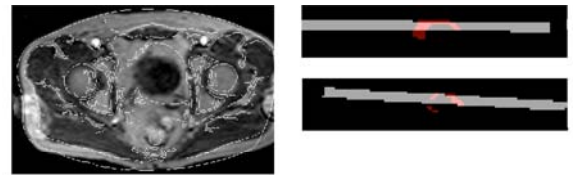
CT edges (Canny edge detector) overlaid onto MR data post-registration. The panels on the right are a visualization in the sagittal and coronal planes of the CT volume (gray) transformed into the MR volume (black) and intersecting the MR tumour ROI (red)
